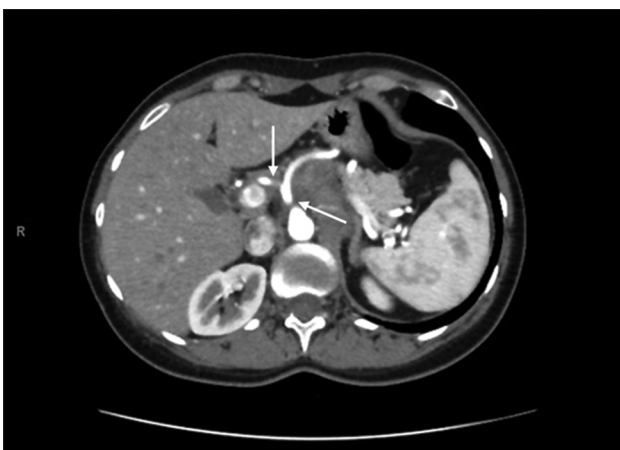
Computed tomography scan performed before radiotherapy showing the persistent disease along the celiac axis and hepatic artery (white arrows).
